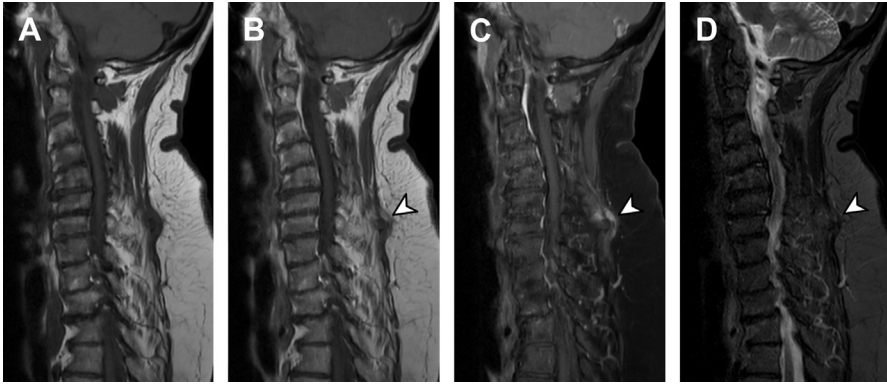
Severe chronic degenerative disease of the cervical spine is seen on nonenhanced T1-weighted image (A). An area of abnormal contrast enhancement is noted in the soft tissue adjacent the C7 spinous process, indicating ongoing inflammatory process (B–D, arrowhead). This abnormality is difficult to distinguish on the regular contrast-enhanced T1-weighted image without fat suppression (B), while it is very conspicuous on contrast-enhanced T1 with fat saturation (C). However, on contrast-enhanced STIR (D), the lesion “disappears” owing to the suppression of the gadolinium signal along with fat signal, demonstrating why it is unwise to perform STIR following the administration of gadolinium-based contrast agent.
